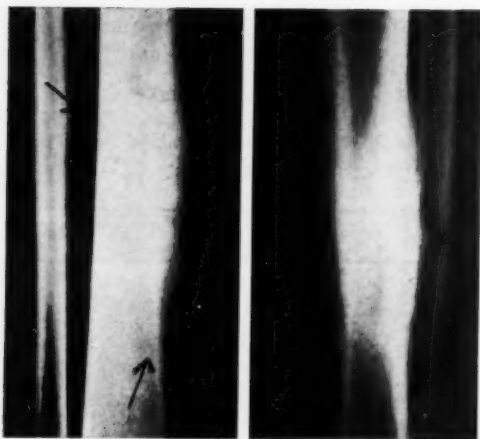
Case 2: Roentgenograms of the left tibia and fibula showing a bone lesion with periosteal reaction and a suggestion of transverse spiculation. A roentgenologic diagnosis of probable osteogenic sarcoma was made. Biopsy revealed a gumma.
